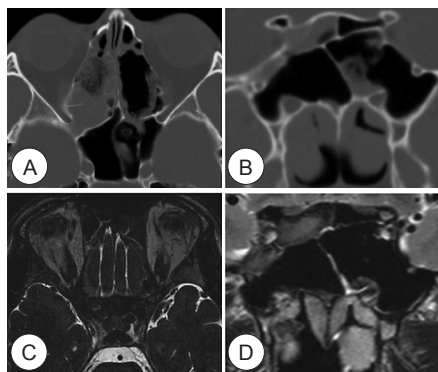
CT and MRI were performed 1 day after surgery. Axial (A) and coronal (B) CT scan showed hemorrhagic opacity, but there was no bony defect. T2 VISTA MRI (C) and T2 coronal MRI (D) demonstrated no abnormal finding at oculomotor nerve pathway, orbital contents and adjacent soft tissues.
